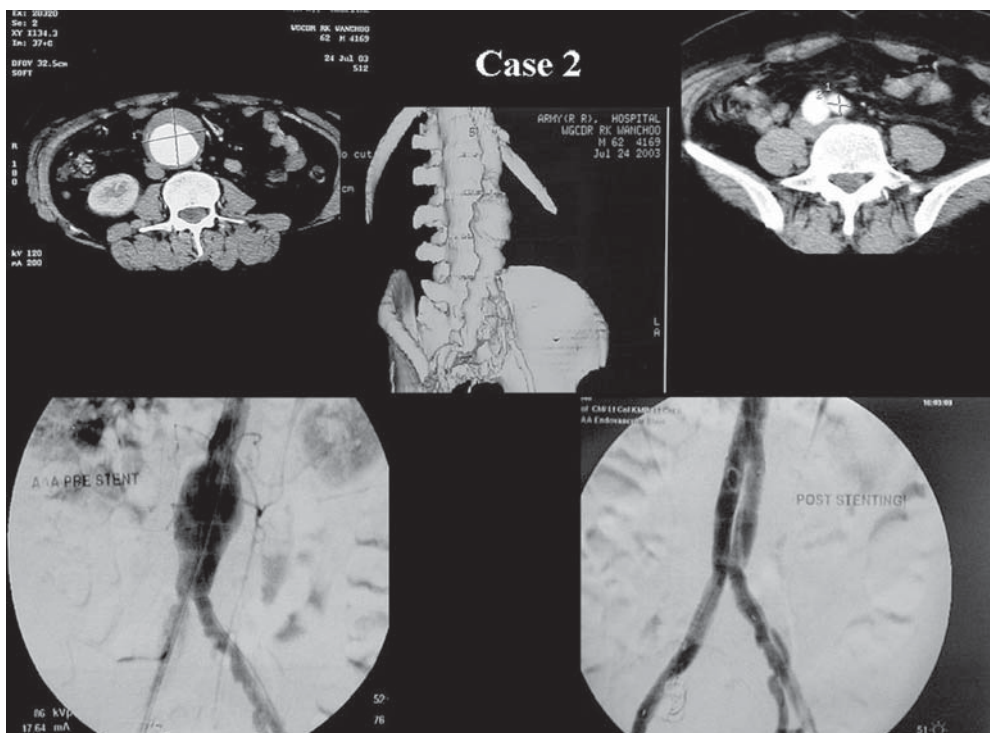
Case 2 (Clockwise) 2(a,b,c) Contrast enhanced CT scan shows an atherosclerotic aneurysm involving infra renal abdominal aorta involving the aortic bifurcation and proximal right common iliac artery. 2(d) Digital Subtraction angiography outlines an infrarenal aneurysm. 2(e) DSA after successful exclusion of the aneurysm by bifurcated stent graft and a tubular extension
